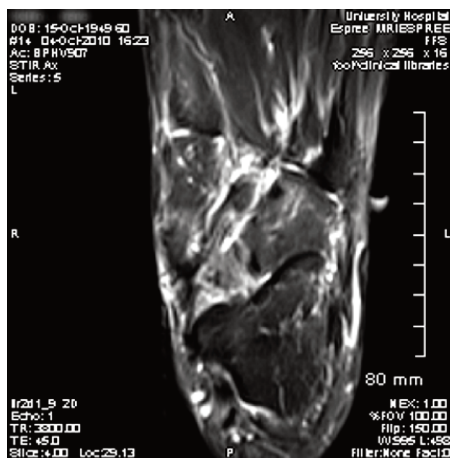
MRI, axial view at 3 months following onset of symptoms.
